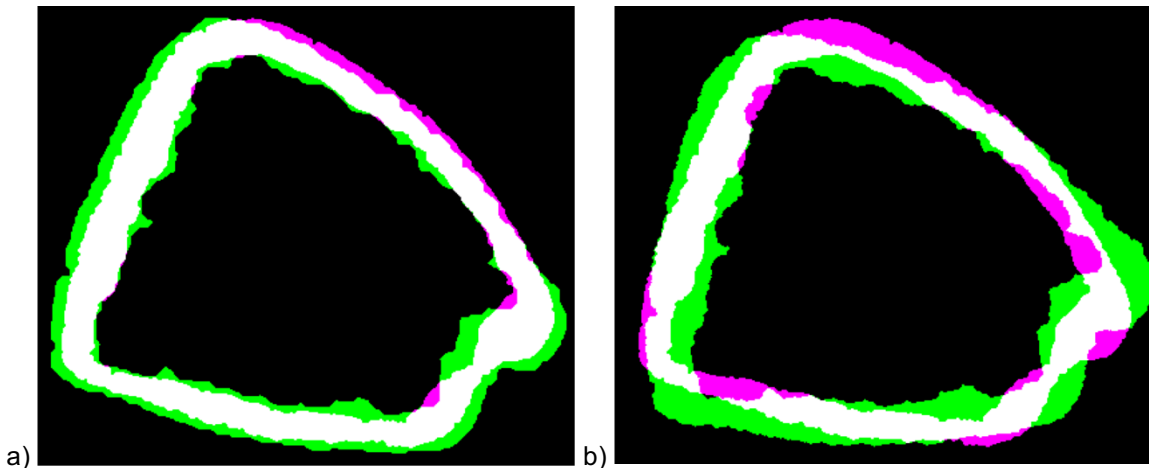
Cortical bone mask comparison of MRI and CT a) original rigid registration result and b) 10° rotation of MRI
